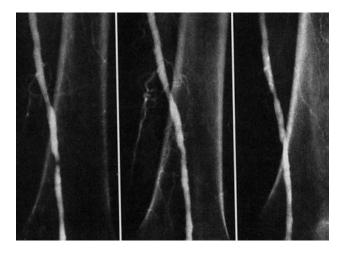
Femoral arteriogram of Dotter's first catheter patient. A. Before dilatation; B. Immediately after dilatation; and C. 3 weeks after the procedure. (From Dotter CT, Judkins MP. Transluminal treatment of arteriosclerotic obstruction. Description of a new technic and a preliminary report of its application. *Circulation* 1964;30: 654–670. Reproduced by permission of the American Heart Association.)
